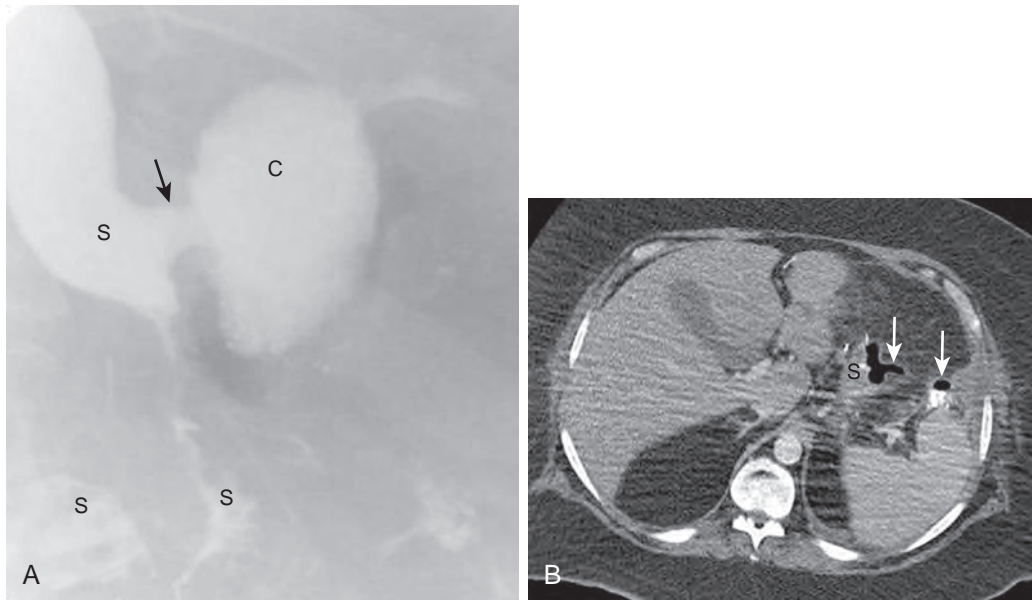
Leak following sleeve gastrectomy. A. UGI image following sleeve gastrectomy shows contrast opacifying an edematous, narrowed, and irregular gastric sleeve (S), with leakage from the proximal sleeve (arrow) into an extraluminal collection (C) extending to the left. Additional amorphous extraluminal contrast is seen more inferiorly. B. Axial CT scan with IV and positive oral contrast shows the leak (arrows) from the gastric sleeve (S) with extraluminal contrast and gas laterally in the left upper quadrant.
